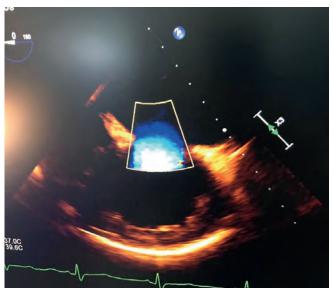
Transesophageal echocardiogram showing a cavity with thin walls from the left ventricular apex.
